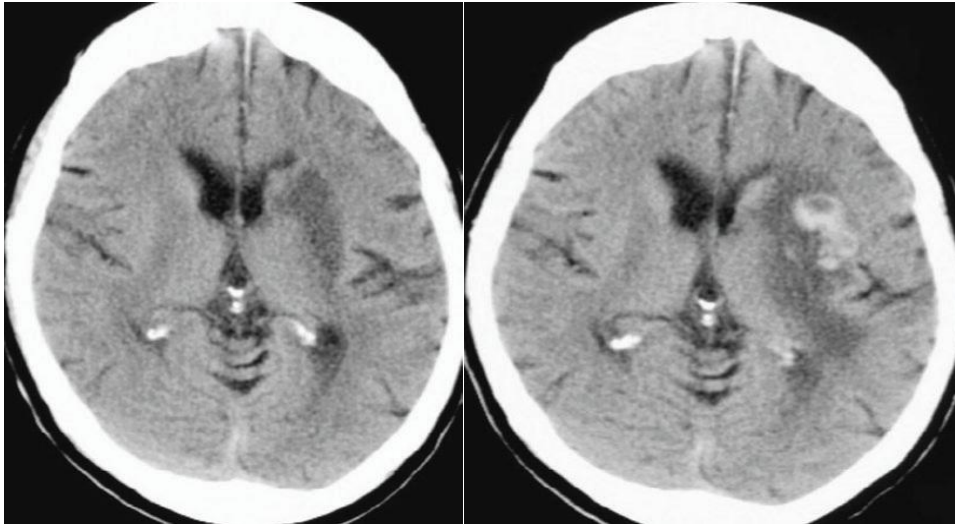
(A) This non contrast CT image demonstrates hypodensity in the left middle cerebral artery distribution, indicating an acute stroke.(B) The next day, after further deterioration in neurologic status, a follow-up CT demonstrates new high-density blood in the same area, indicating hemorrhagic status, (Richard, 2006)
